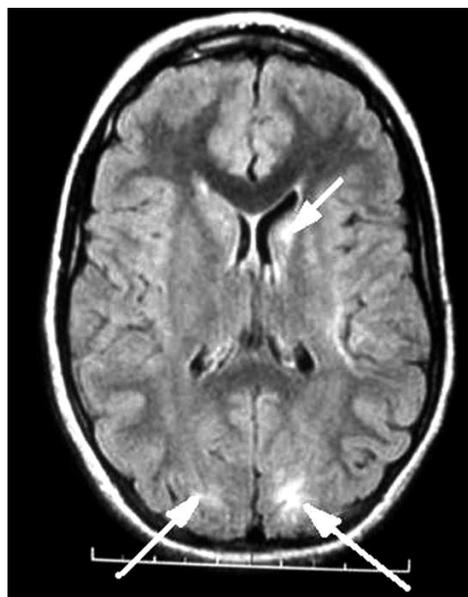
Axial slices of FLAIR magnetic resonance imaging showing a bilateral symmetrical hypersignal in cortical and sub-cortical at the level of Rolando's area and caudate nucleus.
